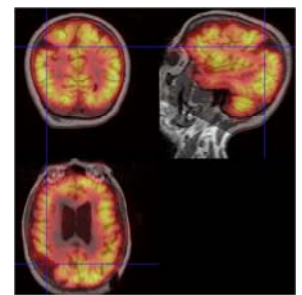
The color SPECT perfusion images co-registered and overlaid on the MR images.
